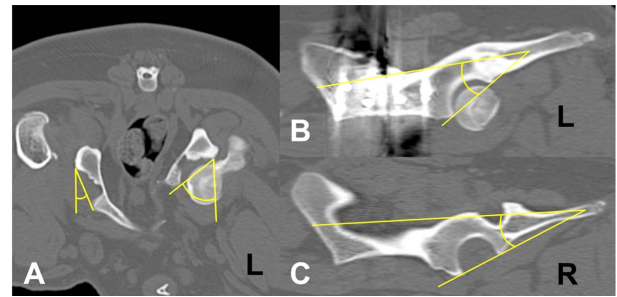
The lateral center edge angle (LCEA) and center distance (CD) has been used as a parameter for hip joint congruity. LCEA is the angle between the connecting line of the dorsal edge of the acetabulum and the center of the femoral head, and appears as a horizontal line on the CT image. CD is the distance between the center of the femoral head and the acetabular center on this CT image. (A) Six months after left hip TPO, the LCEA of the acetabulum was 99.2°. (B) One year after right hip THR, the LCEA of acetabulum was 55.1°. (C) Six months after left hip TPO, the CD of the acetabulum was 1.22 mm. (D) One year after right hip THR, the CD of the acetabulum was 6.56 mm.
